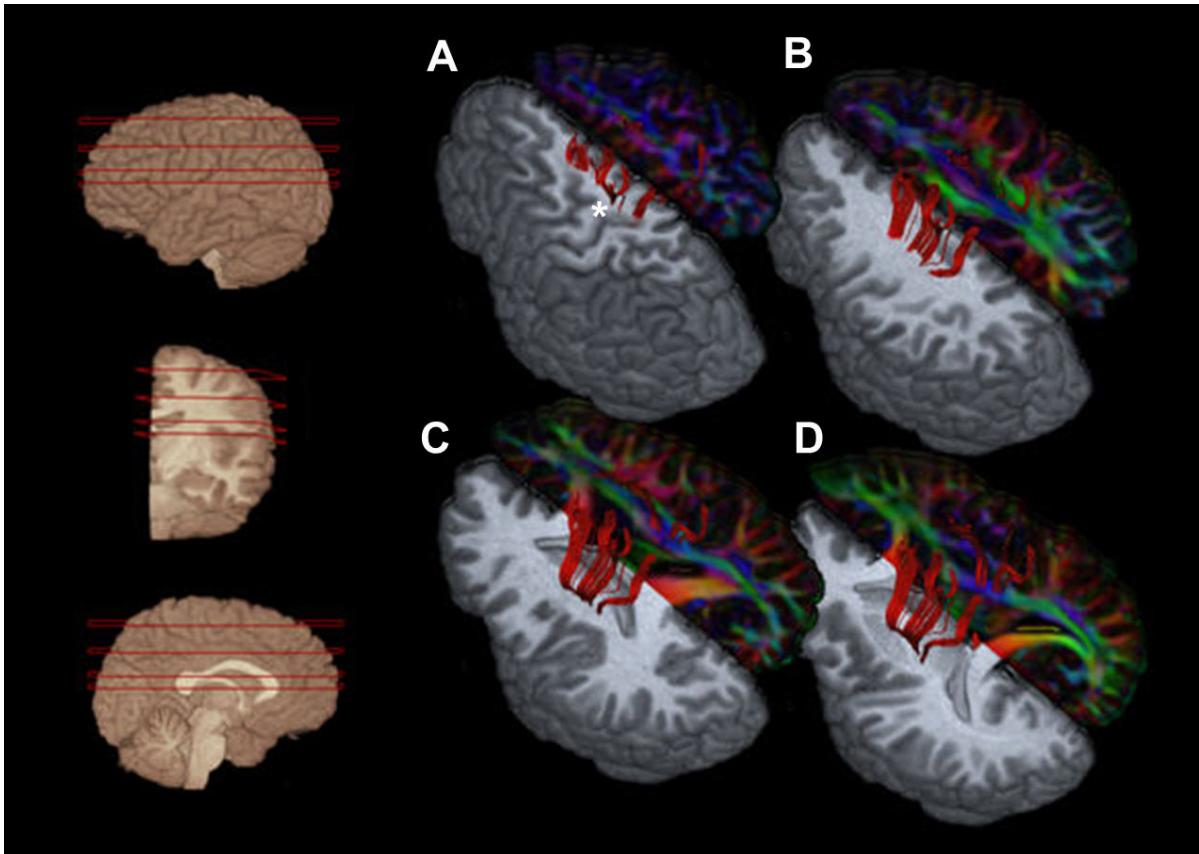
Specific regions evaluated to determine the integrity of the corticospinal tract. Transaxial summed volumetric high-resolution T1-weighted images, FA color-maps, and tractograms show the origin of the corticospinal tract from both the motor cortex (asterisk at precentral gyrus) and primary motor cortex (A). The corticospinal tract involves the centrum semiovale (B) and corona radiata (C) and finally converges at the level of the posterior limb of internal capsule (D). The sectional levels are indicated as red horizontal lines (images on the left).
